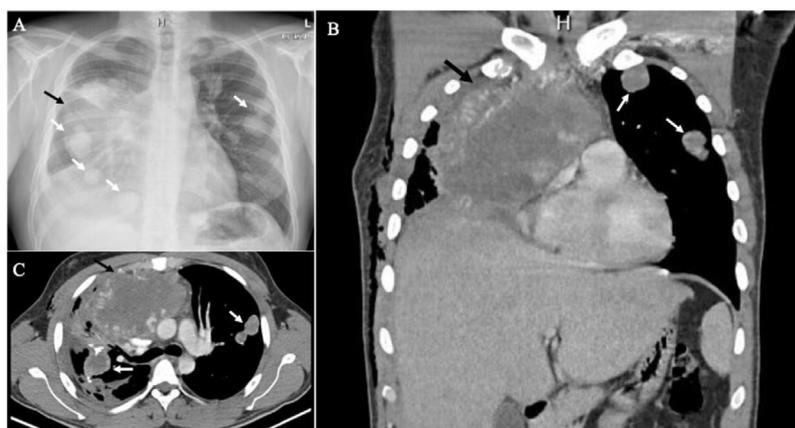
(A) Thoracic X-ray showing a heterogeneous right-sided mass continuous to the mediastinum (black arrow) and multiple pulmonary well-defined opacities (white arrows); (B) Coronal section on thoracic CT-scan showing a heterogeneous solid mediastinal mass (black arrow), touching the right atrium and diaphragm, and two pulmonary solid nodules on the left lung (white arrows); (C) Axial section on thoracic CT-scan presenting the anterior mediastinal mass (black arrow) contacting the ascending aorta, and left and right pulmonary nodules suggesting various metastasis (white arrows).
